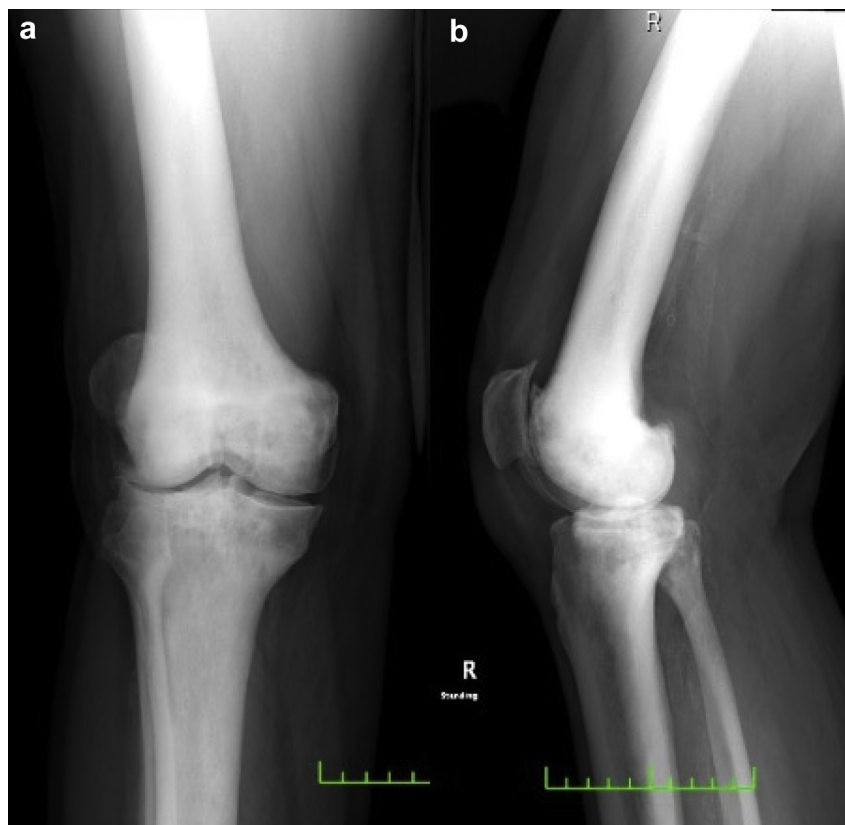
Preoperative radiographs of the right knee. AP (a) and lateral (b) views revealed severe osteoarthritic changes and extensive sclerotic changes of the femur, tibia, and fibula. AP, anteroposterior.
